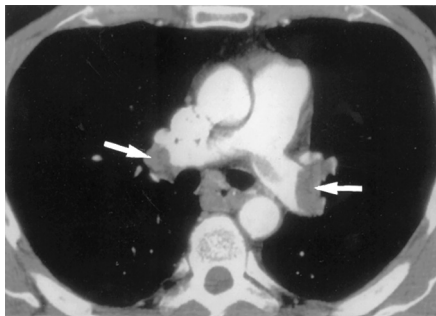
Spiral computed tomographic (CT) image of acute pulmonary emboli (PEs) in both main pulmonary arteries in a postoperative patient who suddenly developed dyspnea, hypoxemia, and hypotension. (From Goldman L, Ausiello D. Cecil medicine. 23rd ed. Philadelphia: Saunders, 2008, Fig. 99-1.)
